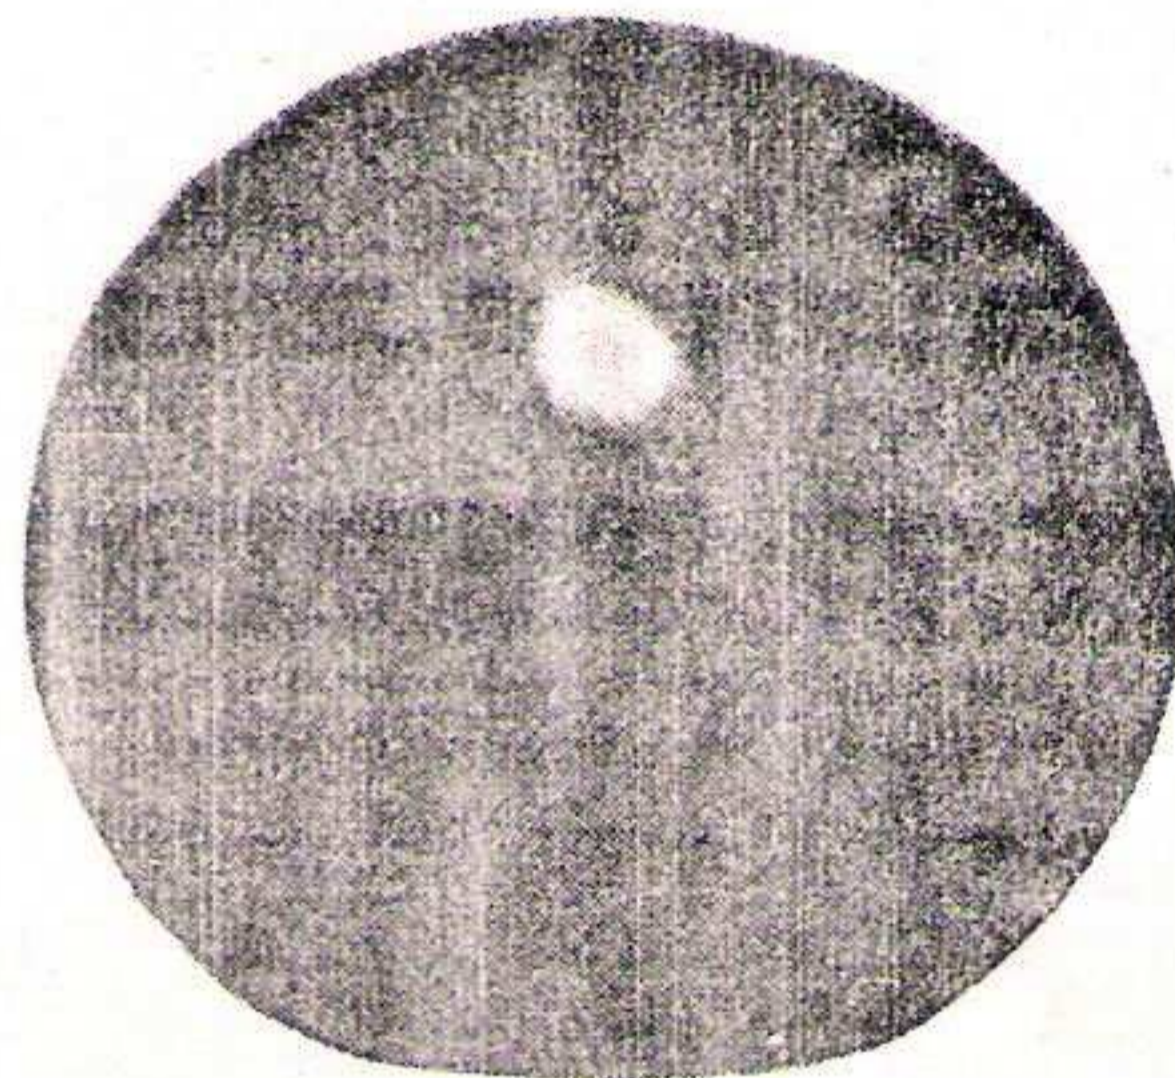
Radiograph of the bigger stone showing the central nidus.
